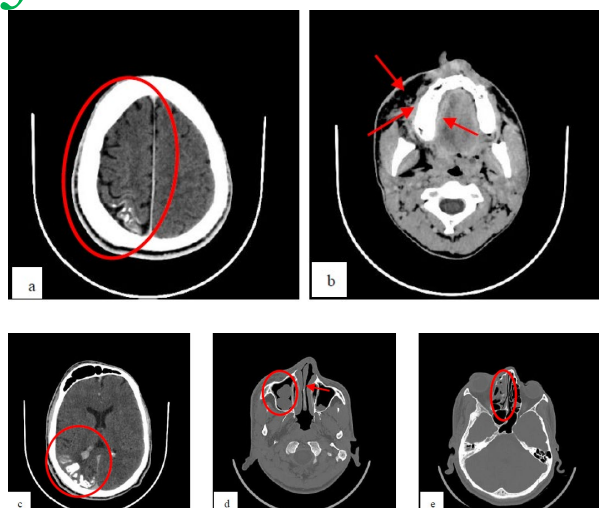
Contrast Enhanced Computed Tomography - Axial Sections of Brain. (a) leptomeningeal enhancement in the right cerebral hemisphere (b) subcutaneous vascular channels in face and hemihypertrophy of right side of maxilla. (c) cortical and sub-cortical tram track like calcifications and enlargement of the right choroidal plexus (d) Polypoidal mucosal thickening in bilateral maxillary sinuses & deviated nasal septum (red arrow) (e) Polypoidal mucosal thickening - ethmoidal sinuses.
